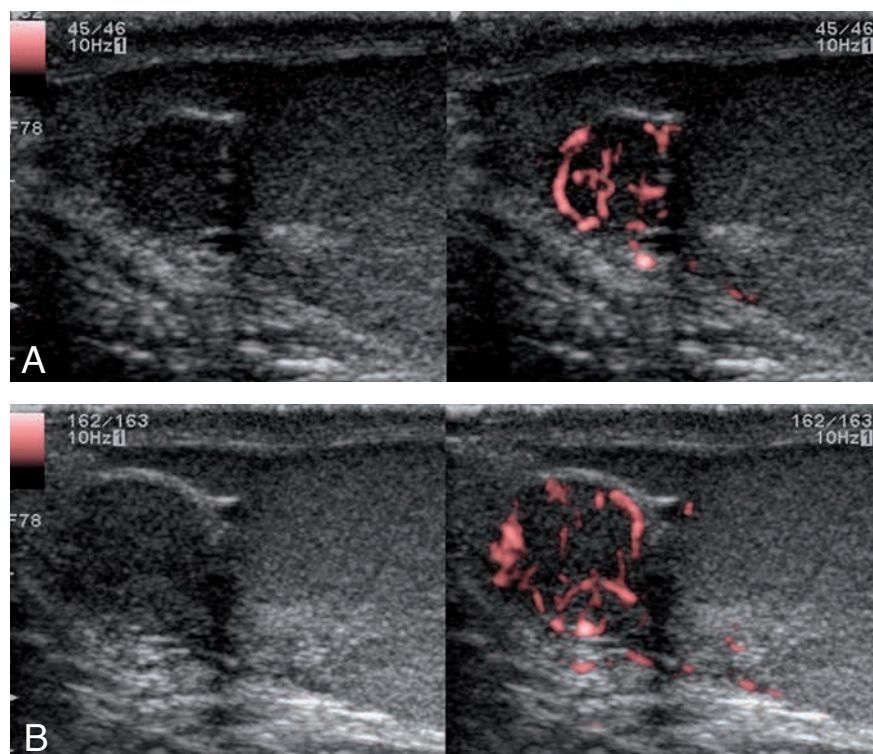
Sonographic gray-scale and corresponding color Doppler images of the upper pole of the left testis and epididymal head, showing a well vascularized nodular lesion in the epididymis (A: initial presentation in 2010, B: follow-up exam in 2013).
